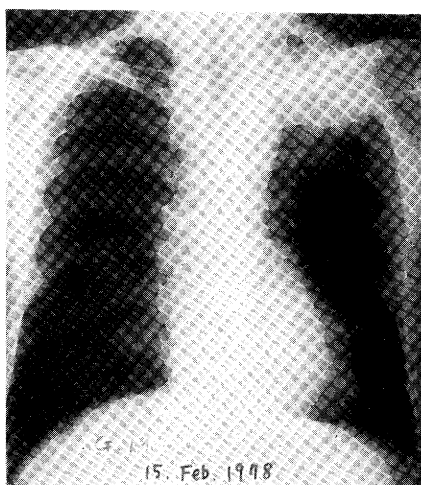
Chest roentgenogram on admission shows a dense infiltration with a cavity accompanied by an air-fluid level in the left upper lobe. (15 Feb., 1978)
